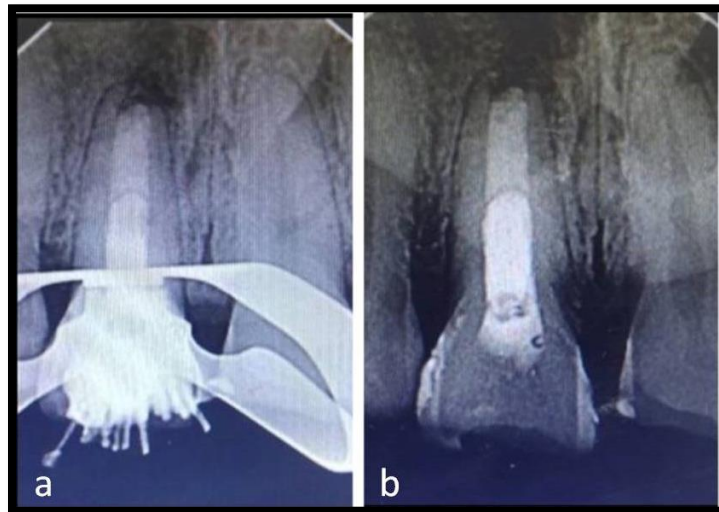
a) Obturation done with Lateral condensation technique. b) Post obturation radiograph
